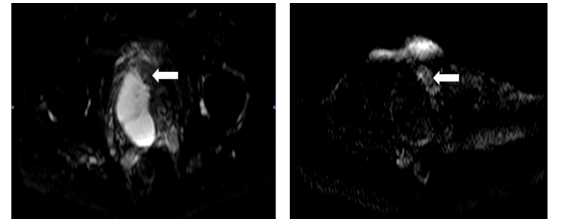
Left: DWI image with zero b-factor. Right: DWI image with b-factor of 1000 shows the bright signal in tumor regions on the dark surroundings.
